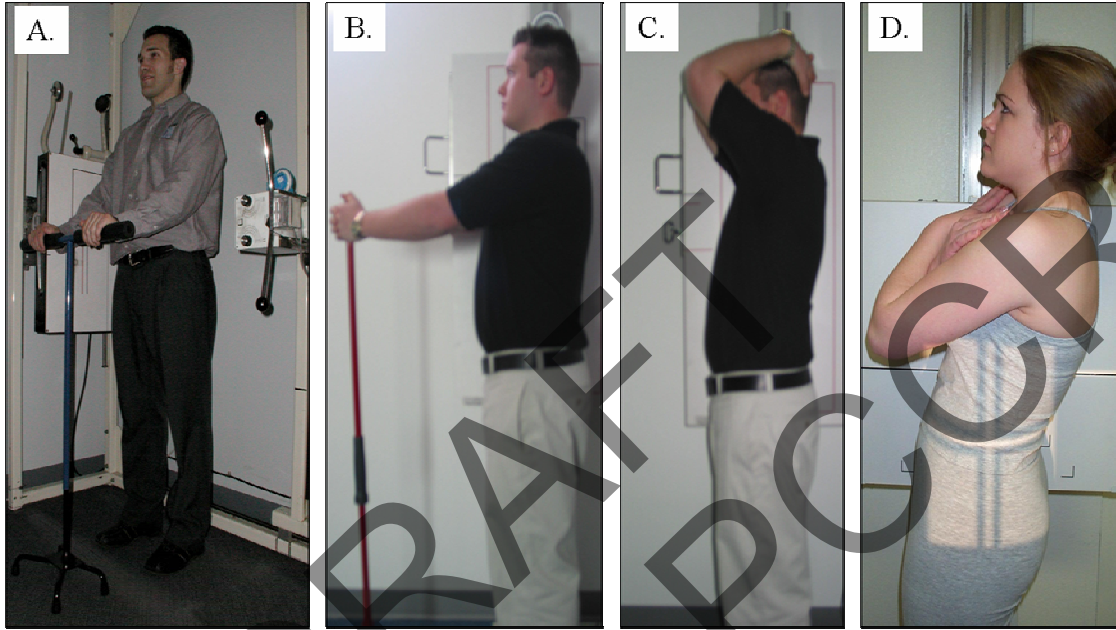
A-D. Self balance position for the lateral thoracic radiograph. In A, the patient assumes their neutral postural balance and then the arms are bent at the elbow and shoulder approximately 135° and the hands are placed on a rest at iliac crest height. In B, the patients arms are flexed nearly 90 at the shoulder and the hands are placed on a pole. In C, the arms are abducted, elbows flexed, and hands folded on the head. In D, the patient assumes the ‘self balance position’ and then the arms are folded on the chest placing the hands in the clavicular fossae.
